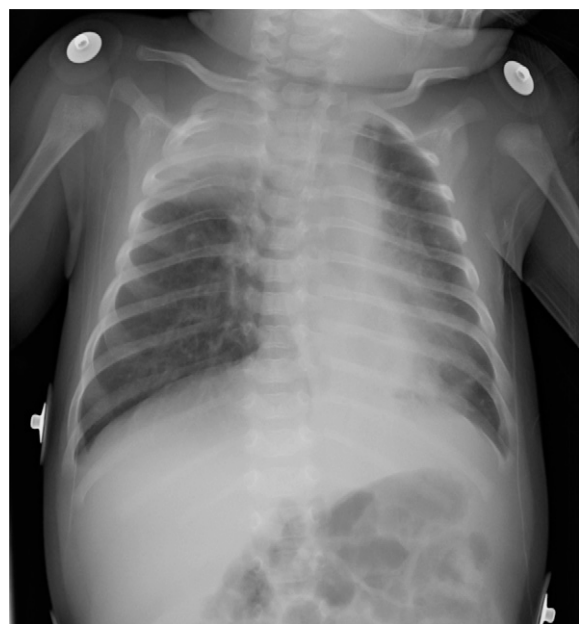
Clinical manifestations of respiratory syncytial virus (RSV). Chest radiography performed in a child with RSV bronchiolitis revealed bilateral hyperinflation from air trapping, patchy atelectasis from airway plugging, and peribronchial thickening from lymphomonocytic infiltration. Patients with severe disease may also have features more consistent with pneumonia, with areas of interstitial parenchymal infiltration.
